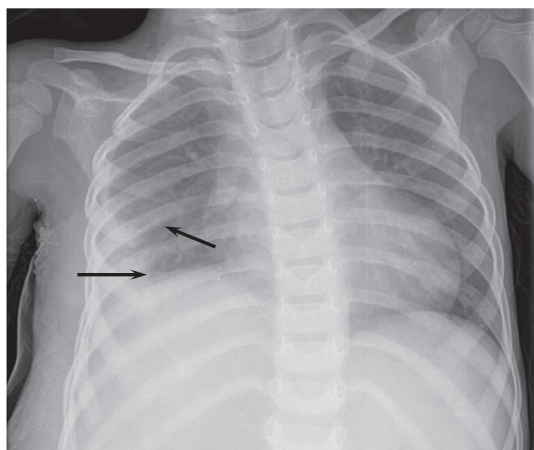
Radiograph demonstrating involvement (both infiltration and destruction) of the right lung and 6th rib (posterior) with a pleural effusion (arrows)
